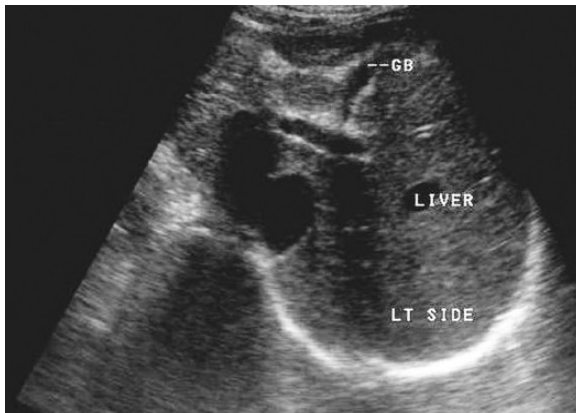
Ultrasound abdomen of patient with Kartagener syndrome showing situs inversus.
